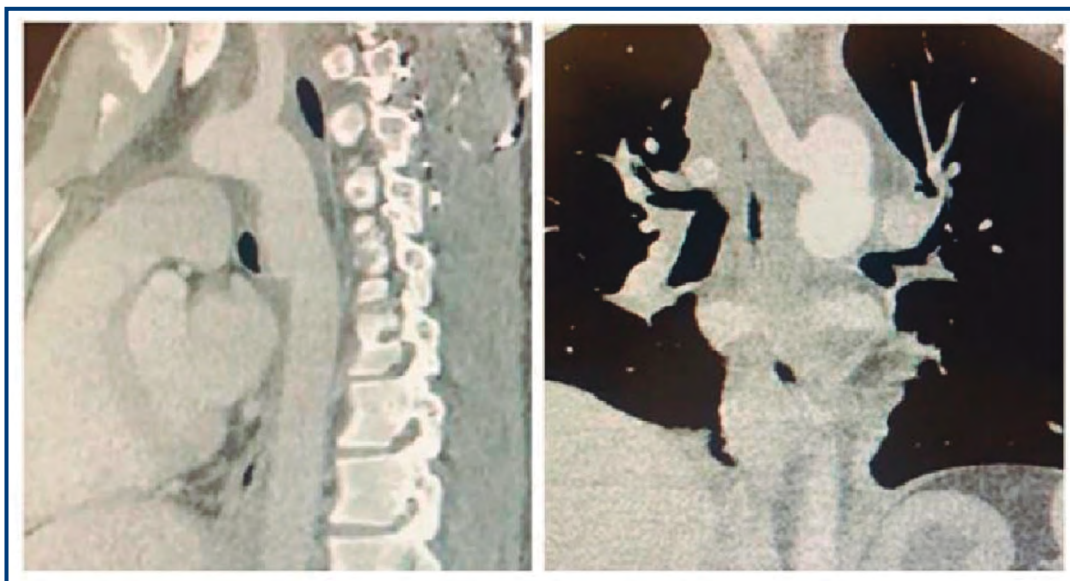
Thoracic CT showing pseudoaneurysm of the descending aorta at the level of the isthmus.
